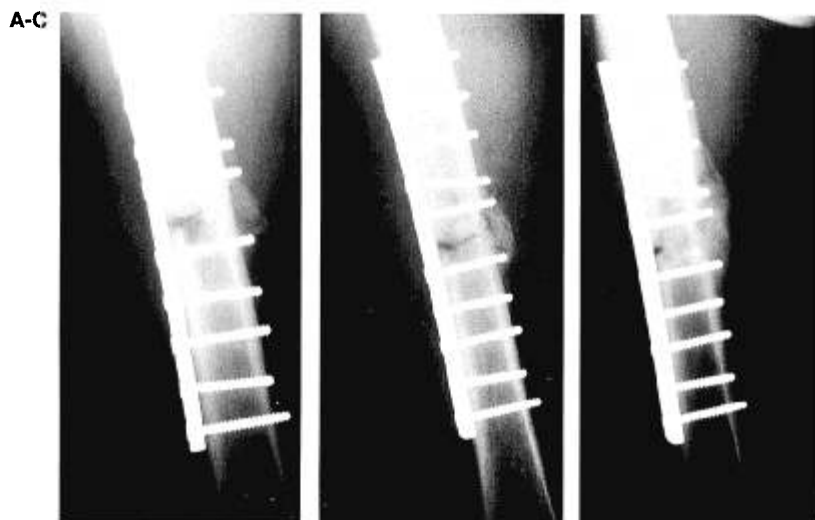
A: Immediate postoperative radiograph of plated femoral diaphyseal fracture with fresh bone graft from Gerdy's tubercle. B: Eight-week postoperative appearance showing early incorporation of bone graft. C: Fracture has united by incorporation of bone graft at 12 weeks. Note that the fracture line is still visible.
